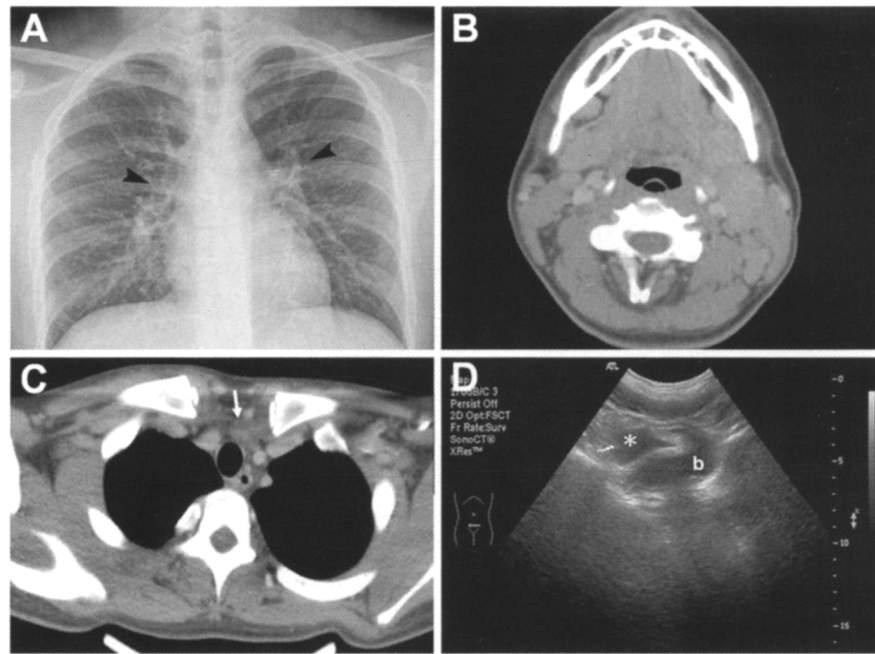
Chest x-ray revealed infiltration and moderate prominence of the bilateral hilar regions (arrowheads on *A*). The coronal computed tomography scan revealed multiple enlarged lymph nodes at bilateral neck (*B*) and superior mediastinum (arrow on *C*). Abdominal sonography revealed the existence of ascites (asterisk on *D*, b = bladder).
